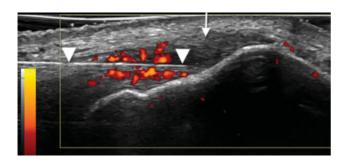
A 55-year-old man with lateral elbow pain. Longitudinal sonogram of the common extensor tendon (arrow) of the lateral elbow shows thickening and hypoechogenicity. Power Doppler shows hyperemia in red. A 22G needle (arrowheads) is inserted into the tendon during platelet-rich plasma treatment.
